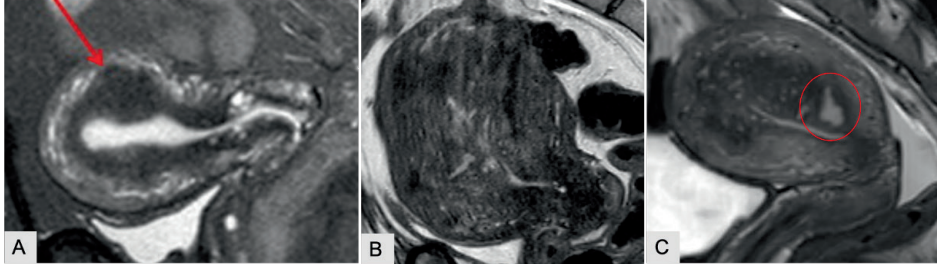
Examples of MRI subtypes (on MRI), A. Focal adenomyosis concentrated in the posterior wall (red arrow) B. Diffuse adenomyosis affecting the whole uterine wall C. Cystic adenomyosis with islands of endometrial tissue in the myometrium (largest cystic focus circled in red). (Images taken from own study populations).
